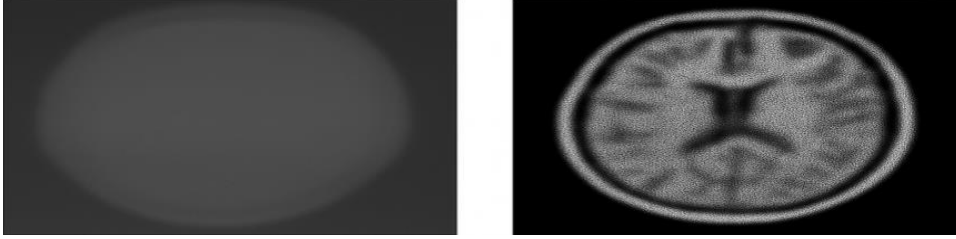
Effect of Adaptive Histogram Equalisation (AHE) on MRI slices. AHE. (a) Original Image. (b) After AHE.
